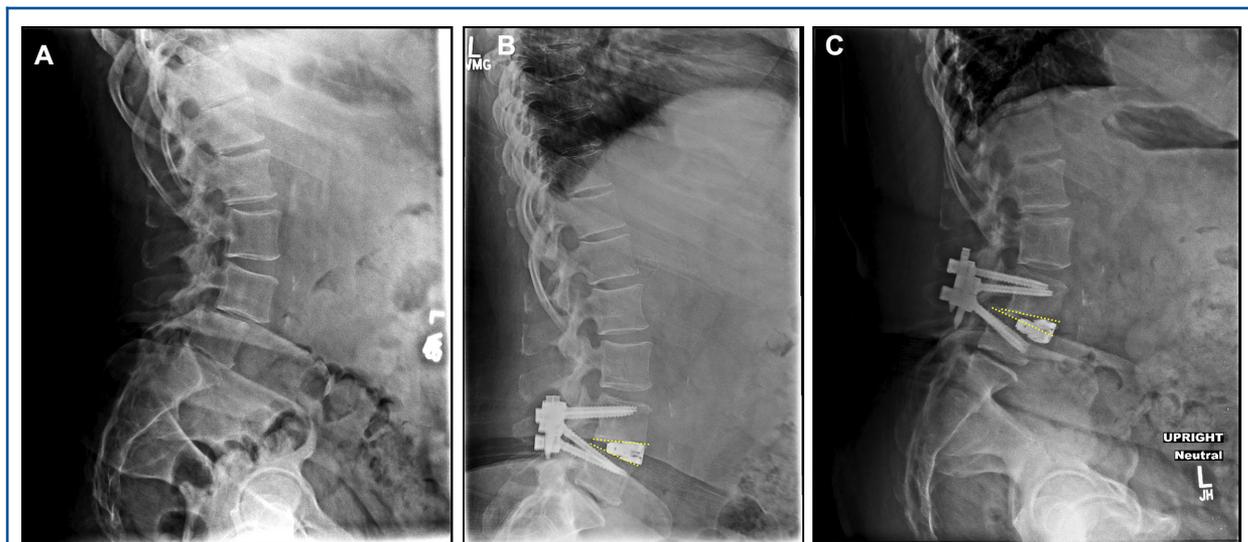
Upright lateral radiographs taken A, preoperatively, B, postoperatively on day 1, and C, 6 wk following transfacet MIS-TLIF at L4-L5. Radiograph at 6 wk shows subsidence of the expandable interbody device into the caudal endplate and new grade II anterolisthesis of L4 on L5. The patient subsequently underwent revision surgery with removal of the posterior instrumentation, followed by anterior lumbar interbody fusion.
